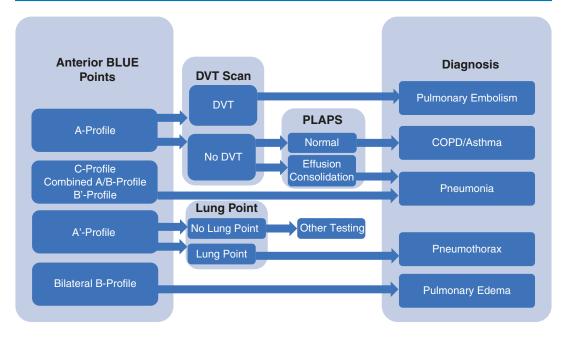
The Bedside Lung Ultrasound in Emergency (BLUE) Protocol [25]
